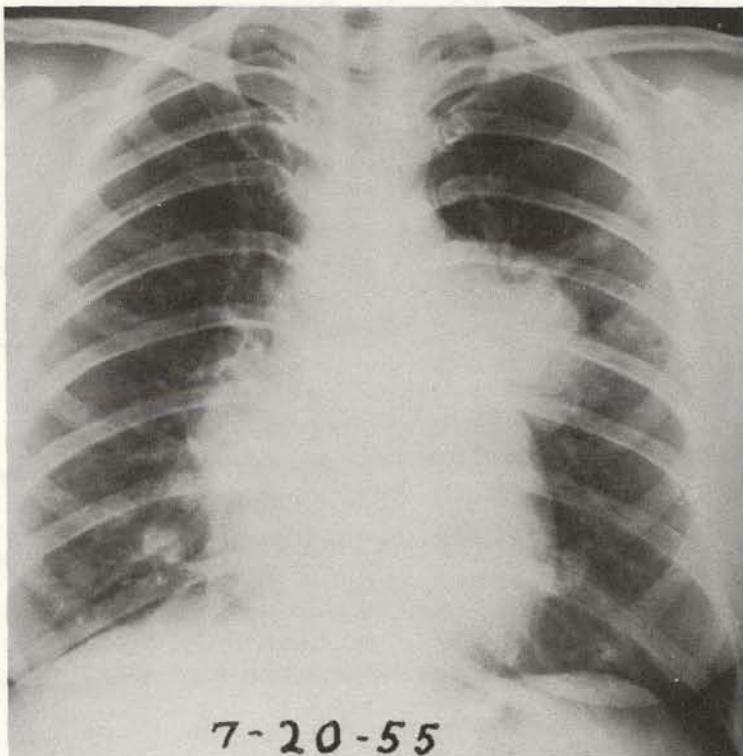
Roentgenograph of chest, July 20, 1955, 7 years after total thyroidectomy for papillary carcinoma, of a 48-year-old woman. On June 21, 1955, I^{131} uptake was 40% in 24 hrs., chiefly in neck; I^{131} treatment, 30 mc. On July 20, 1955, I^{131} treatment, 30 mc.
